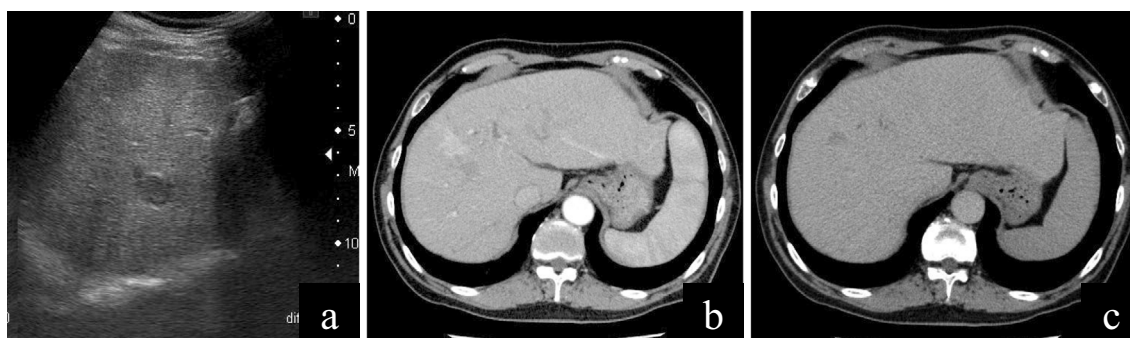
(a) Ultrasonography revealed that the tumor (segment 7) exhibited low echogenicity. (b, c) Early-phase computed tomography revealed hyperenhancement and a decrease to hypoenhancement during late-phase computed tomography (high-low).
